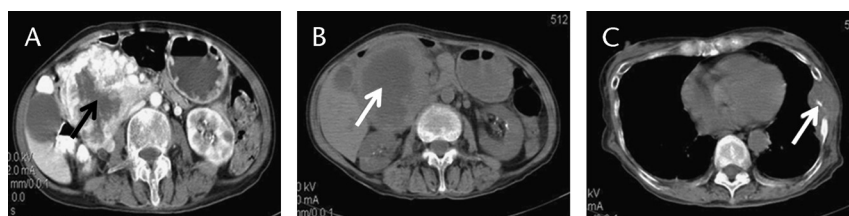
Main treatment process and curative effect of the mother. A, CT scanning of the abdomen 2 months after TAE; the arrow shows the tumor of the pancreatic head. B, Computed tomographic scanning of the abdomen 18 days after cryosurgery; the arrow shows the tumor of the pancreatic head. C, Computed tomographic scan of the chest 4.5 months after cryosurgery; the arrow shows the site of the tumor of the left side of the chest wall.
